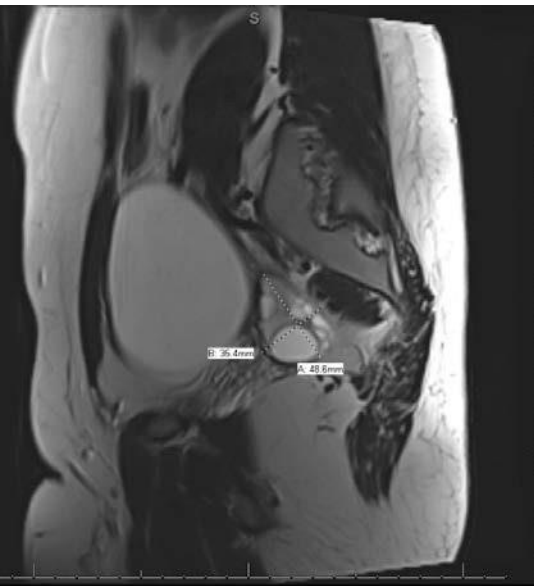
MRI with contrast image: Sagittal view Left ovary was seen separately measuring 35.4 mm x 48.6 mm
